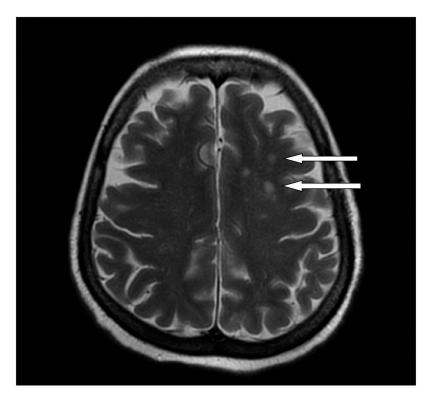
Magnetic resonance imaging of brain (FLAIR) showing abnormal signal intensities.
